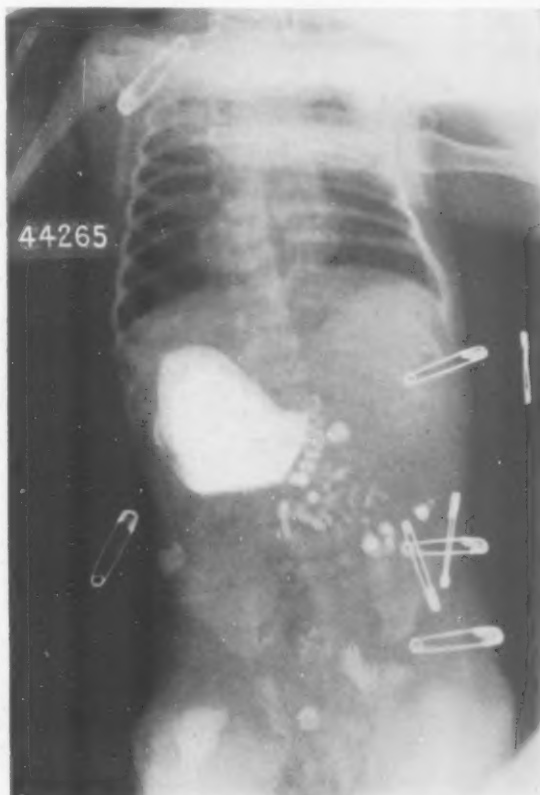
On roentgenologic examination a small but definite amount of barium was seen to pass intermittently out of the pyloric end of the stomach while the major portion of the meal remained in the stomach.
